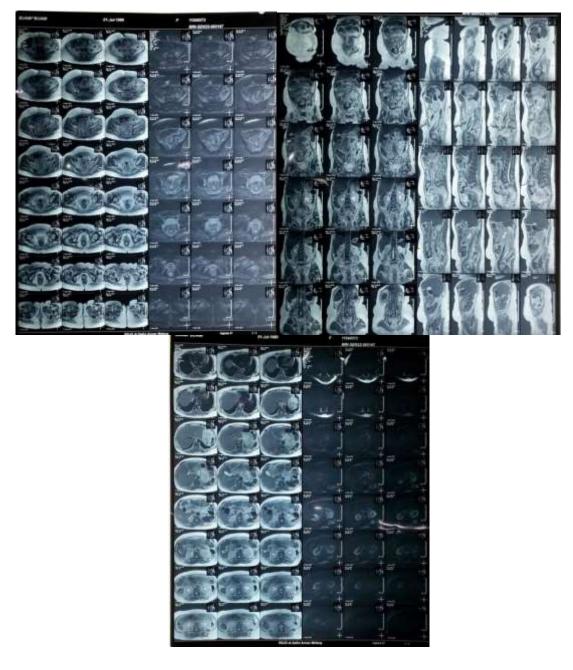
MRI Abdomen Examination of the patient's
